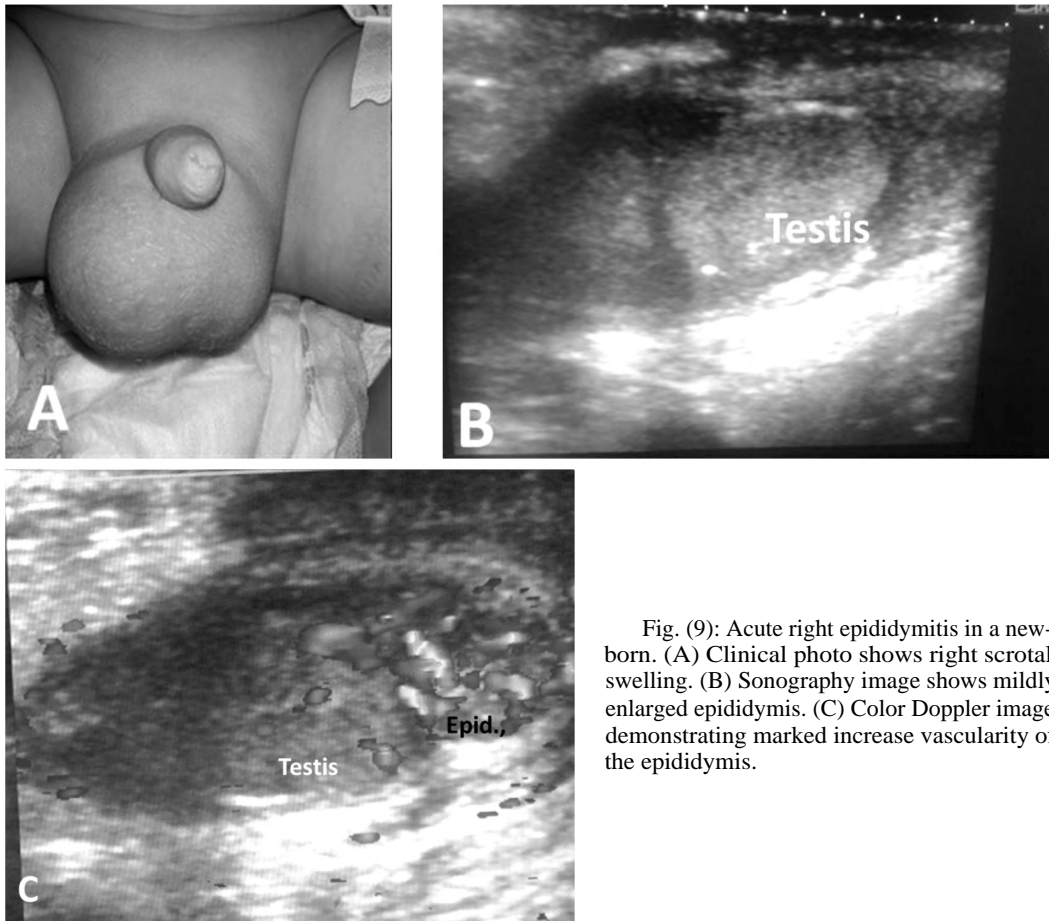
Acute right epididymitis in a newborn. (A) Clinical photo shows right scrotal swelling. (B) Sonography image shows mildly enlarged epididymis. (C) Color Doppler image demonstrating marked increase vascularity of the epididymis.
